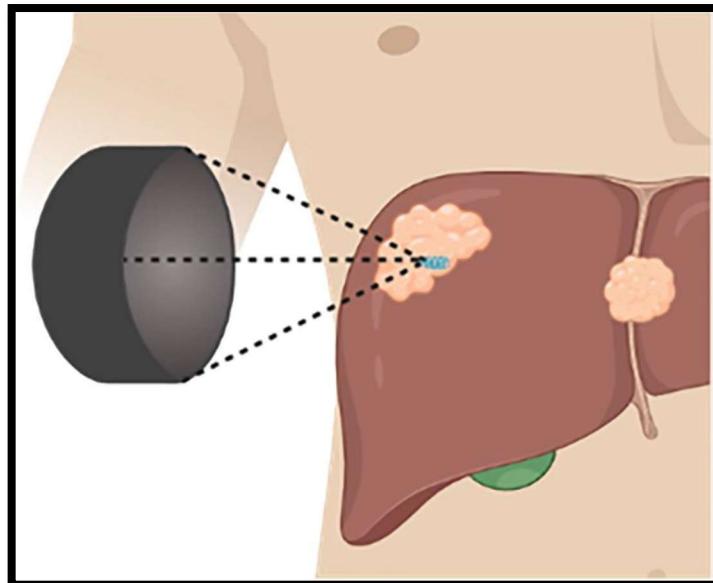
Therapeutic ultrasound transducer positioned outside of the body, focuses ultrasound waves within a targeted tissue generating a cavitation bubble cloud.
